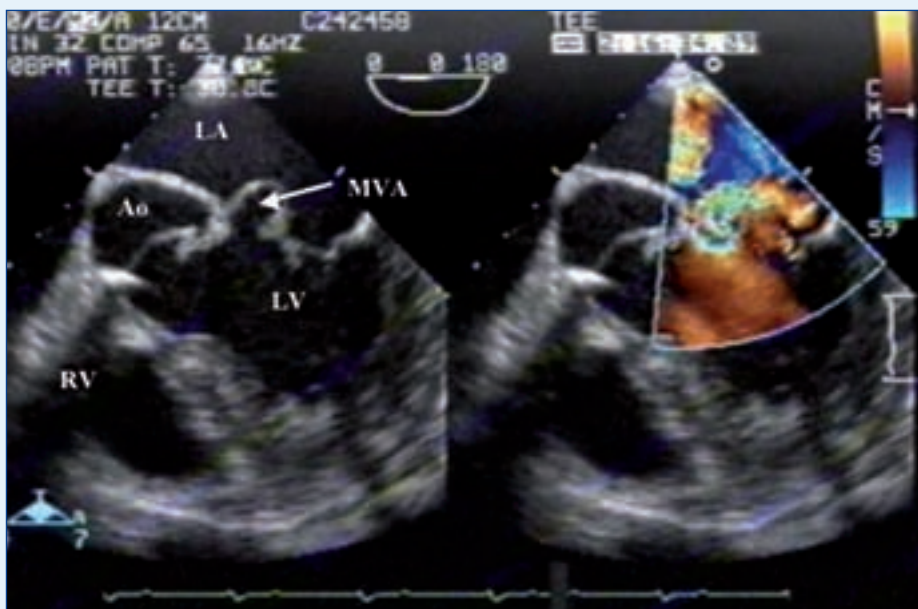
a. Transoesophageal echo, with (b) Doppler demonstrating a mitral valve abscess and the associated turbulent flow around it. Ao = aorta; MVA = mitral valve abscess; LA = left atrium; LV = left ventricle; RV = right ventricle.
